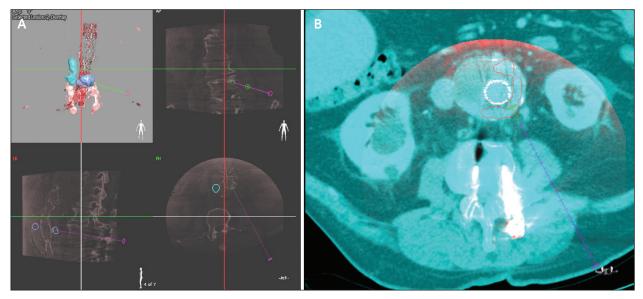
Needle path planning using preoperative CTA (A). The entry point is selected at the level of septal fenestration connecting the false lumen nidus with the true lumen nidus (B).
